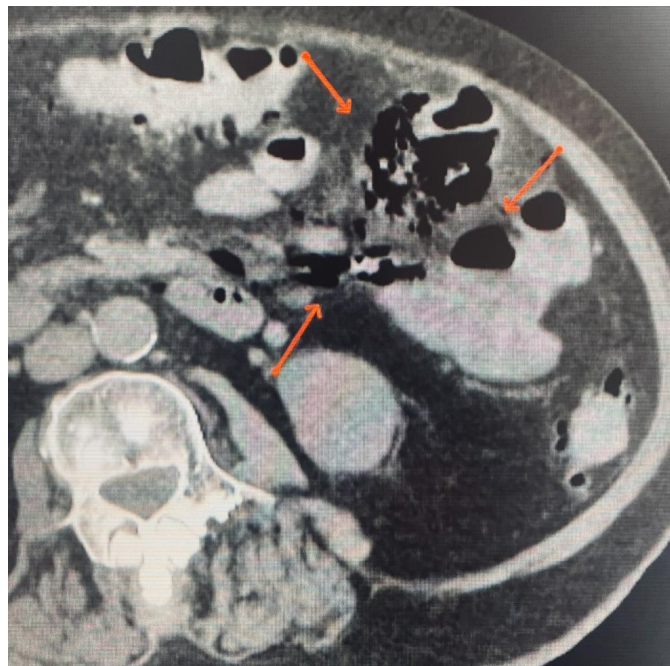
Axial abdominal CT revealing air inside a blocked abscess.
